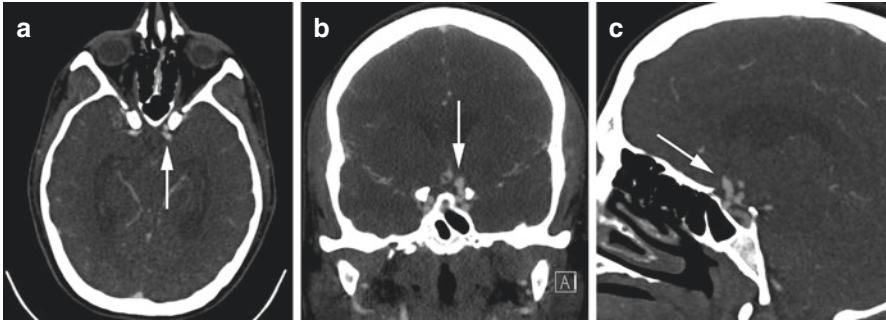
Ophthalmic segment aneurysm. Patient with a left ophthalmic segment aneurysm. Axial (a), coronal (b) and sagittal (c) CTA showing a superiorly projecting left ICA ophthalmic segment aneurysm (arrow)
